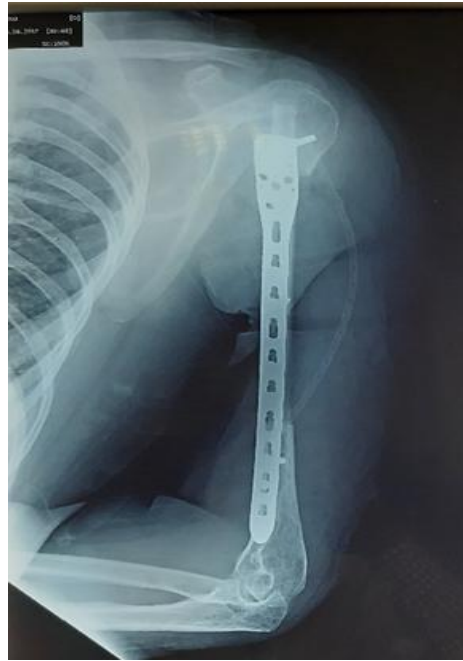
Post-operative radiograph showing the fibular graft stabilized by a locked plate
